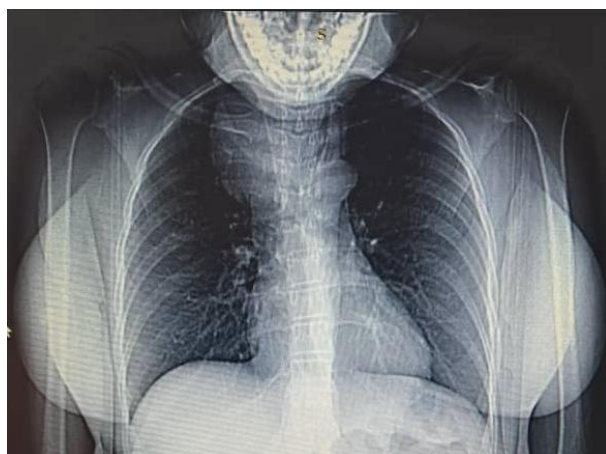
Pre-operative chest x-ray- superior mediastinal opacity
